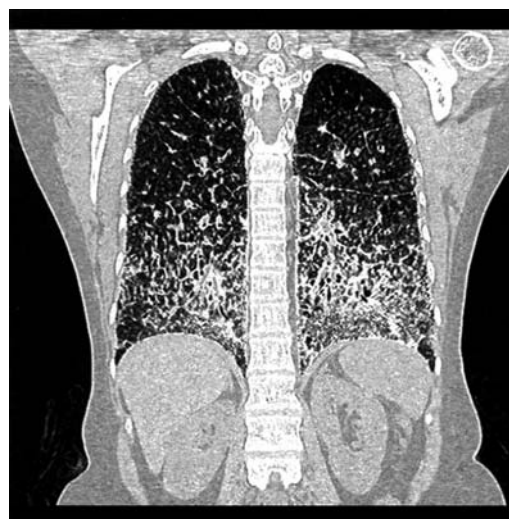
Axial section of high resolution computed tomography of chest showing the predominant involvement of lower portions of the lungs with extensive calcification.
